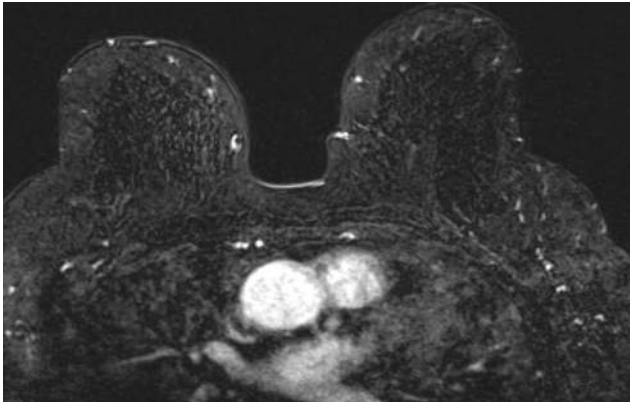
MRI exam. Contrast-enhanced subtraction MR image upper left breast in the area of concern based on tomo views shows no abnormal enhancement.
